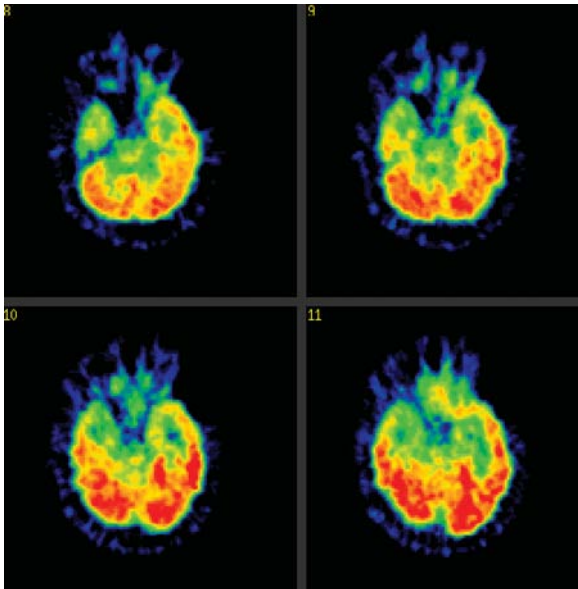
¹⁸FDG-PET scan showing focal hypometabolism.
